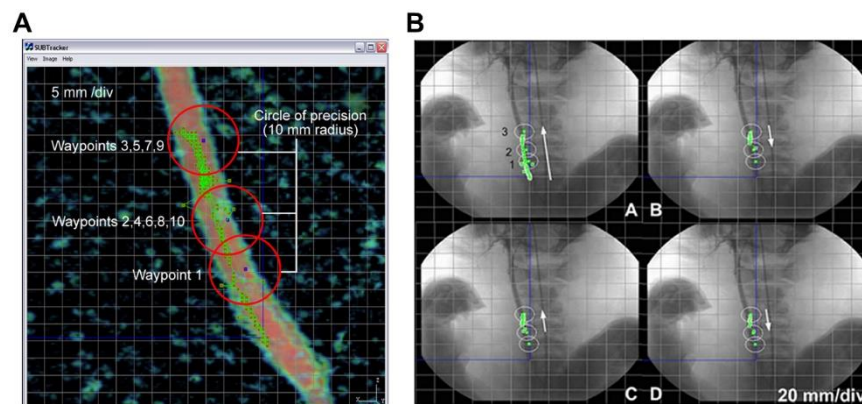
Automated tracking of a chrome steel sphere. The intended path of the sphere was defined using three waypoints and passed from waypoint 1 to 3, before moving backwards and forwards between waypoints 2 and 3. The sphere was considered to have reached the waypoint once within a surrounding circle of precision (10 mm radius). A The software in which the path is defined and sphere movement is tracked (Chanu and Martel, 2007). B Sphere trajectory superimposed over an x-ray angiography. The green dots show actual displacement of the sphere. Arrows indicate the direction of movement. (Martel *et al.*, 2007)
